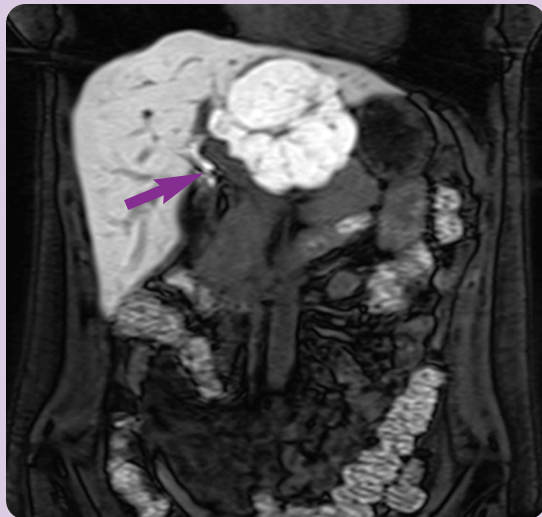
Coronal T1-weighted fat-saturated 3D gradient echo image acquired 20 minutes post-administration of hepatocellular-specific contrast agent. A large FNH is seen in the left hepatic lobe, which is hyperintense compared to the rest of the liver. Note also the biliary excretion of the GBCA (arrow). Courtesy of Dr. Elmar Merkle, Duke University Hospital.
